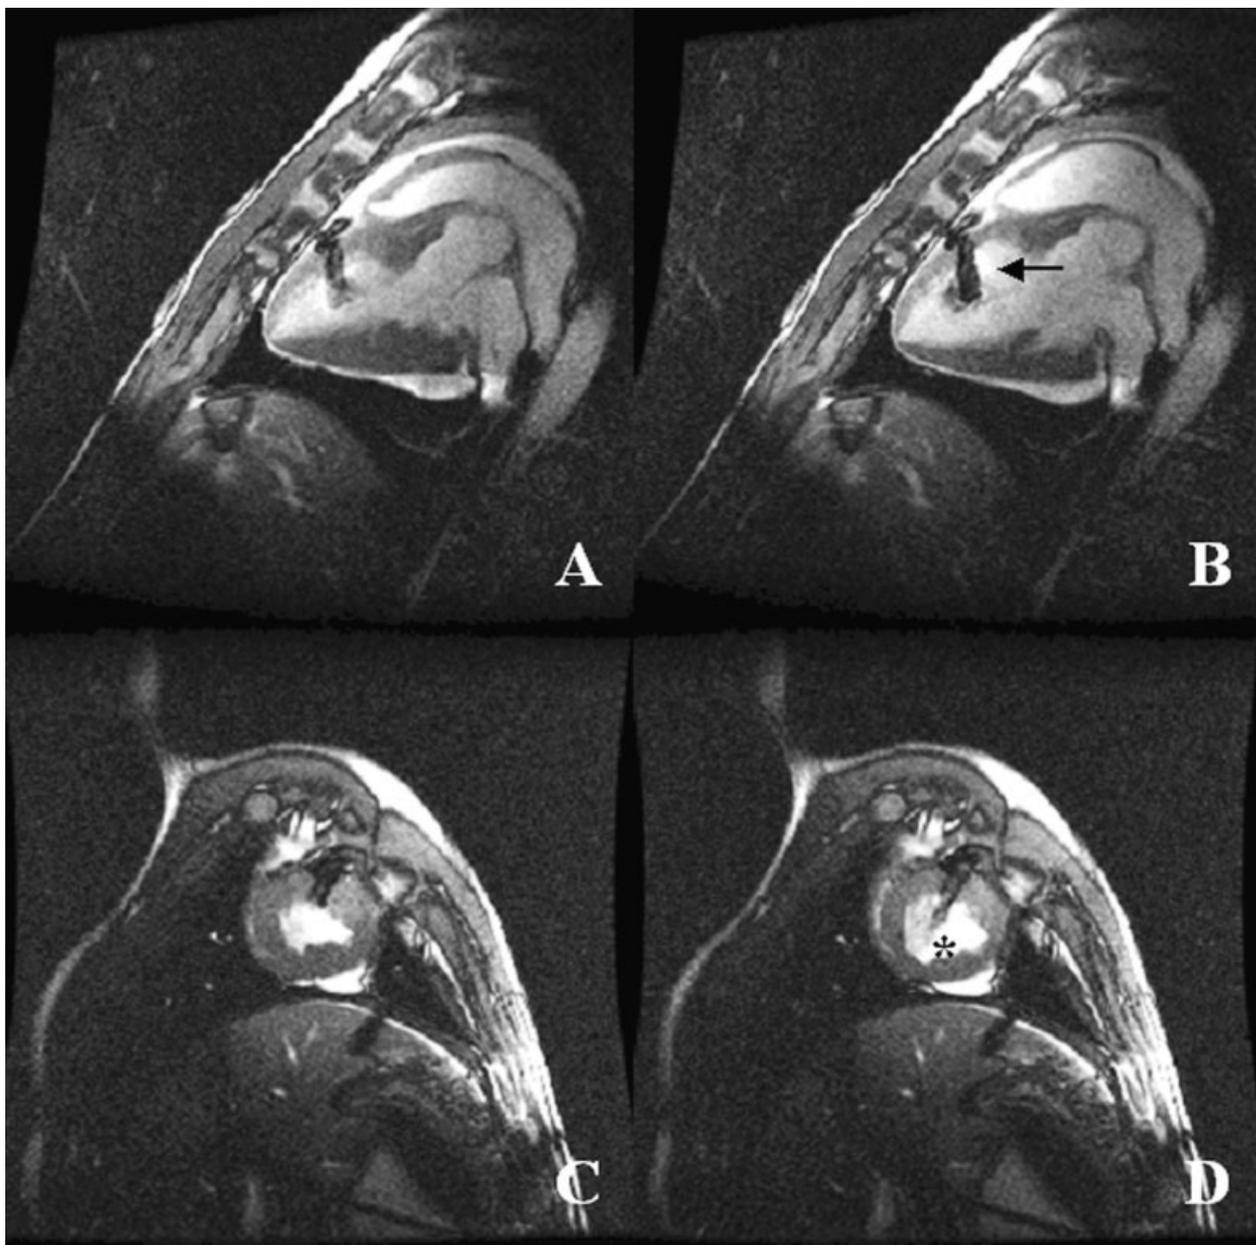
FIESTA MR images 1 month post-VPASS and LAD occlusion. Upper images show long-axis view in systole (A) and in diastole (B). Lower images show short-axis view in systole (C) and in diastole (D). Black arrow indicates the VSTENT artifact (B). The flow (star) is coming back through the VSTENT into the LV in diastole (D).
